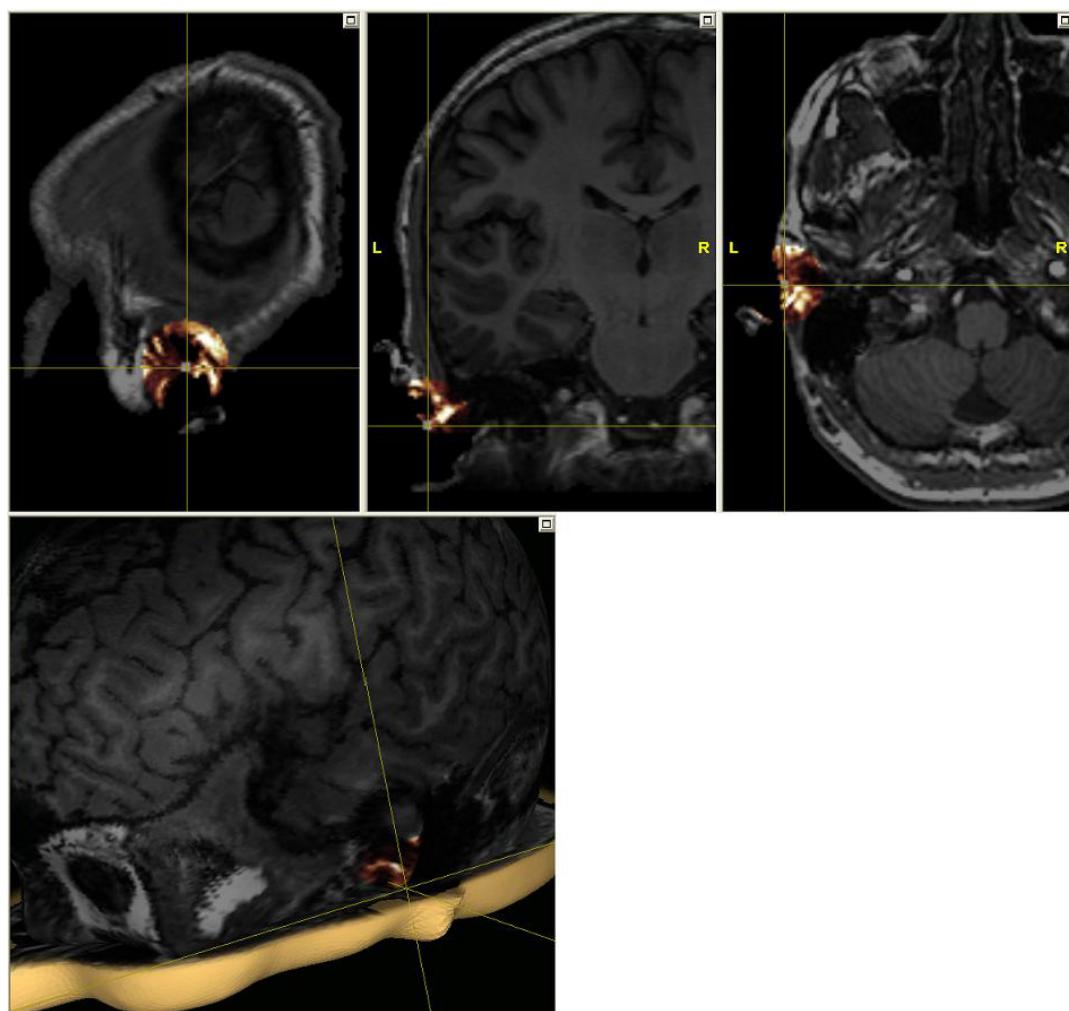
Heat colormap: Location of the left ear landmark in MR images and 3D head
